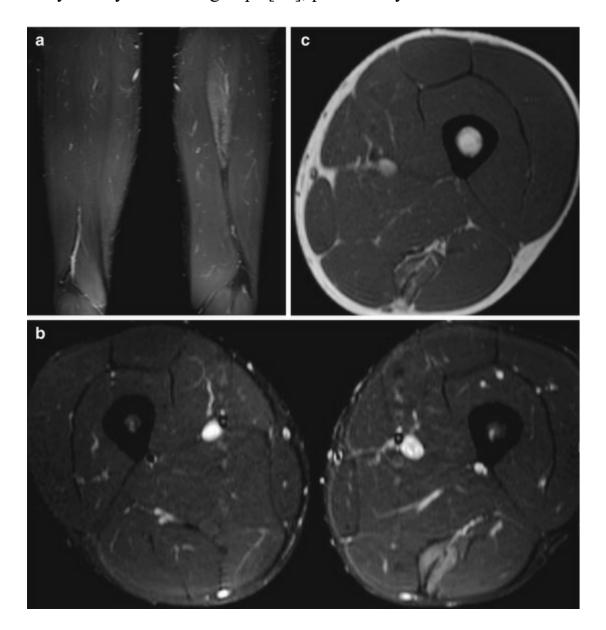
A 19-year-old male professional soccer player with chronic injury of the semitendinosus muscle. Coronal (a) and axial (b) STIR MRI show hyperintensity and atrophy of the semitendinosus muscle with a longitudinal, hypointense scar. Axial T1-weighted MRI (c) reveals fatty infiltration, indicating an old injury
